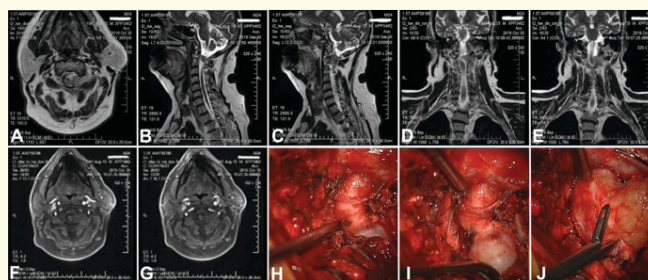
Giant SNST, multinodular ventral tumor growth (VTG), growth in the spinal canal and compression of the spinal cord. Lateral curvature of the cervical spine towards the tumor: Antero-lateral approach, removal of the paravertebral part of the tumor. Exposure of the vertebral artery at the C5-C6 level, corpectomy C6, partly C5, removal of the tumor in the spinal canal, decompression of the spinal cord, corporodesis C5-C7 with a cage, fixation with a plate. MRI before surgery and 7 days after surgery. Total removal of the tumor. A - axial MRI T1, T2, B - frontal MRI T2, C - axial MRI T2, T1, frontal MRI T2 after surgery, D - sagittal MRI T2, T1 after surgery, E - axial MRI T2 after surgery.
